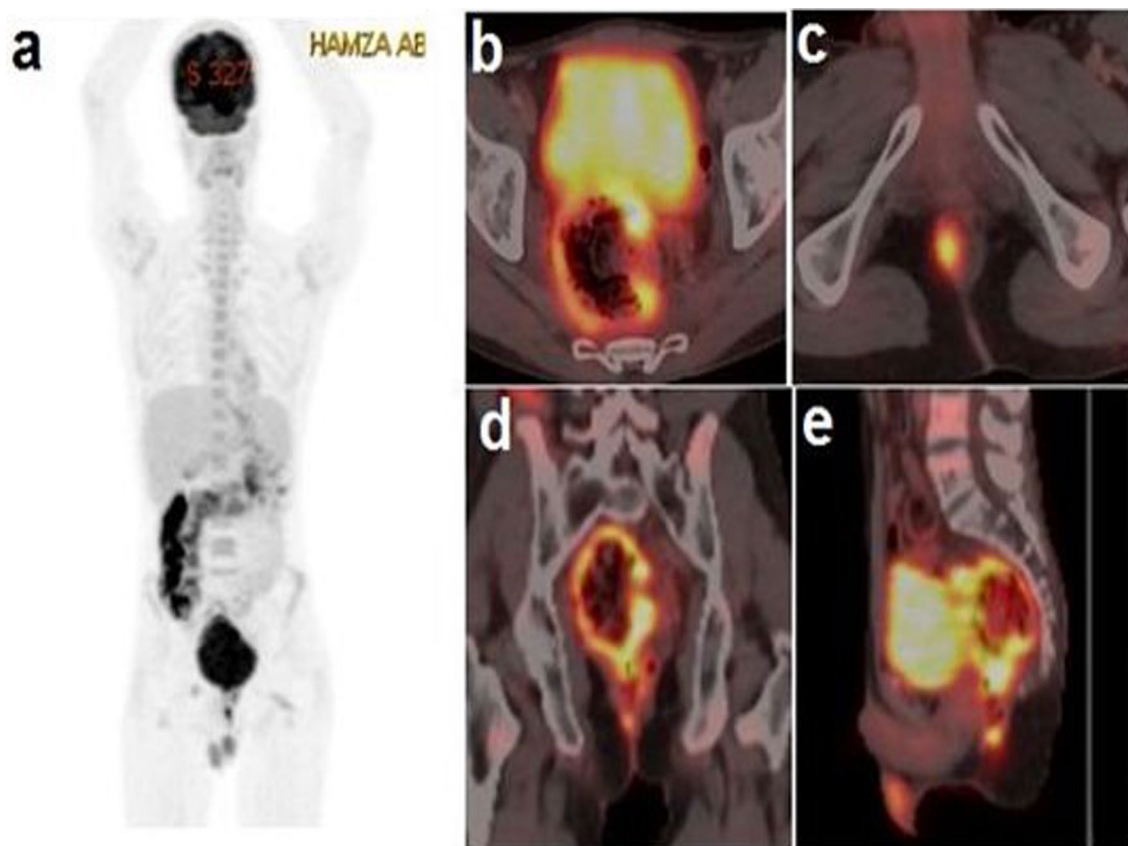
a–e PET/CT study for the same patient in Fig. 7. a MIP and b–e fused PET/CT images revealed metabolically active (FDG avid) circumferential polypoidal mural thickening is seen involving the entire length of the rectum and rectosigmoid junction measuring about 2.2 cm at max thickness and 12 cm at max length with max SUV ~ 17.26, surrounded by fat smudging. Metabolically active (FDG avid) soft tissue nodule is seen at the right side of the anal canal measuring about 2.5 cm with max SUV ~ 9.79. Low grade metabolically active right inguinal lymph node is seen measuring about 1 cm with max SUV ~ 3.05 which increased to 3.6 on delayed scan
